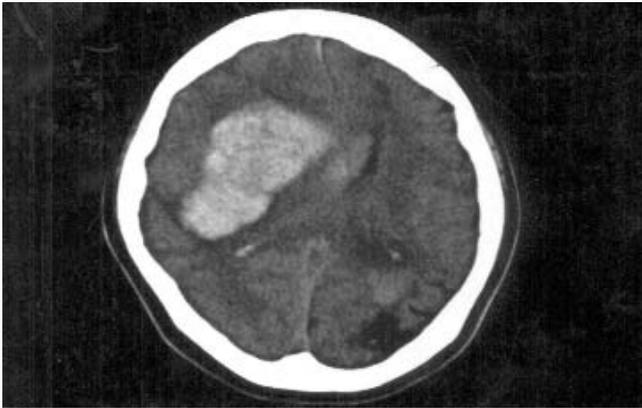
Head CT on arrival
